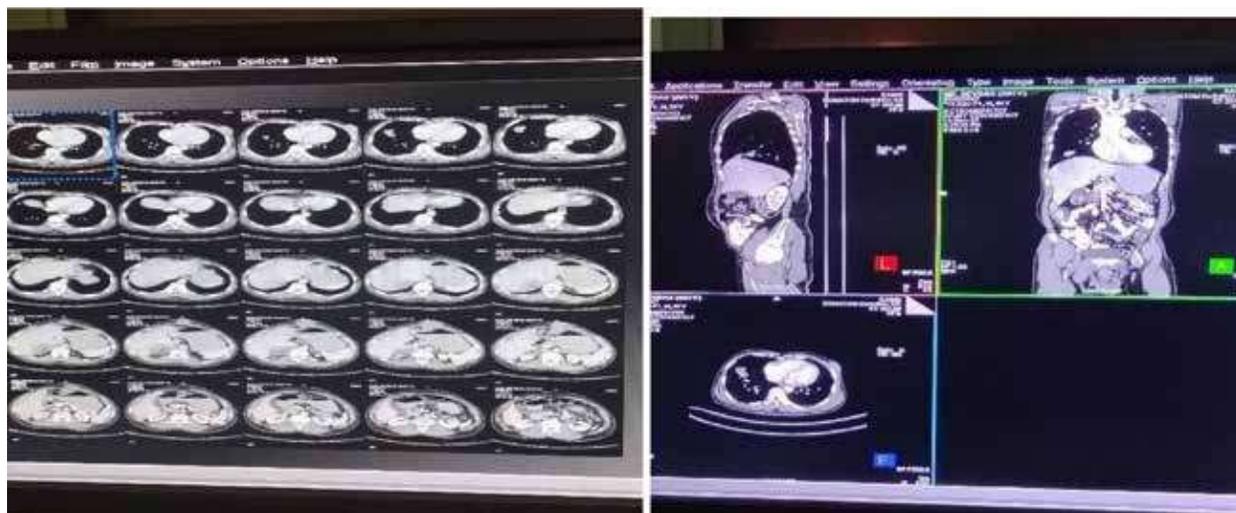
CT chest and abdomen showing mass in right lower lobe and right suprarenal lesion
